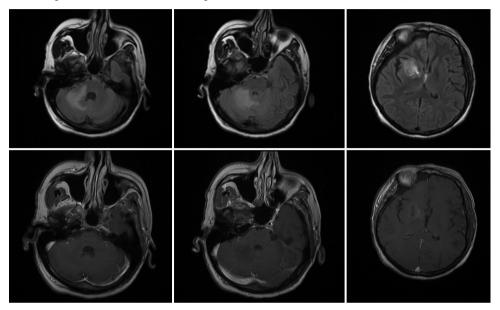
FLAIR-weighted images and contrast enhanced T1-weighted images of patient 2 who was HIV (+) and had Toxoplasma encephalitis FLAIR: Fluid-attenuated inversion recovery, HIV: Human immunodeficiency virus
